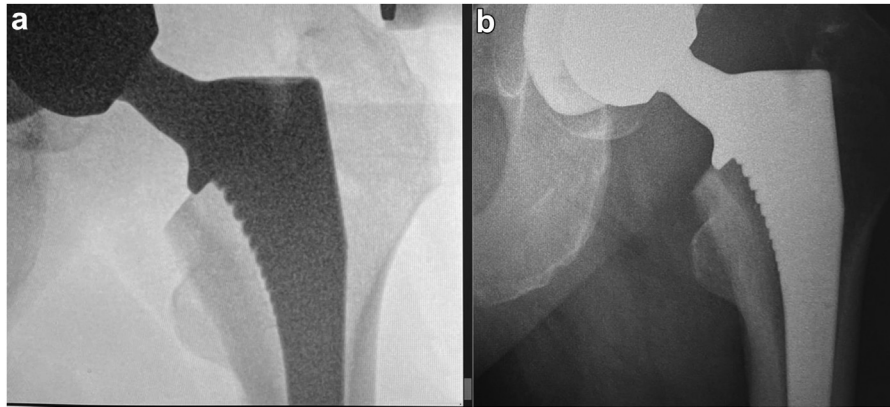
(a) Primary THA patient without collar-calcar contact shown on intraoperative fluoroscopy vs (b) 3 mm stem subsidence shown on an 8-week postoperative radiograph. Measurable subsidence occurred in 19.0% of patients without initial collar-calcar contact.
